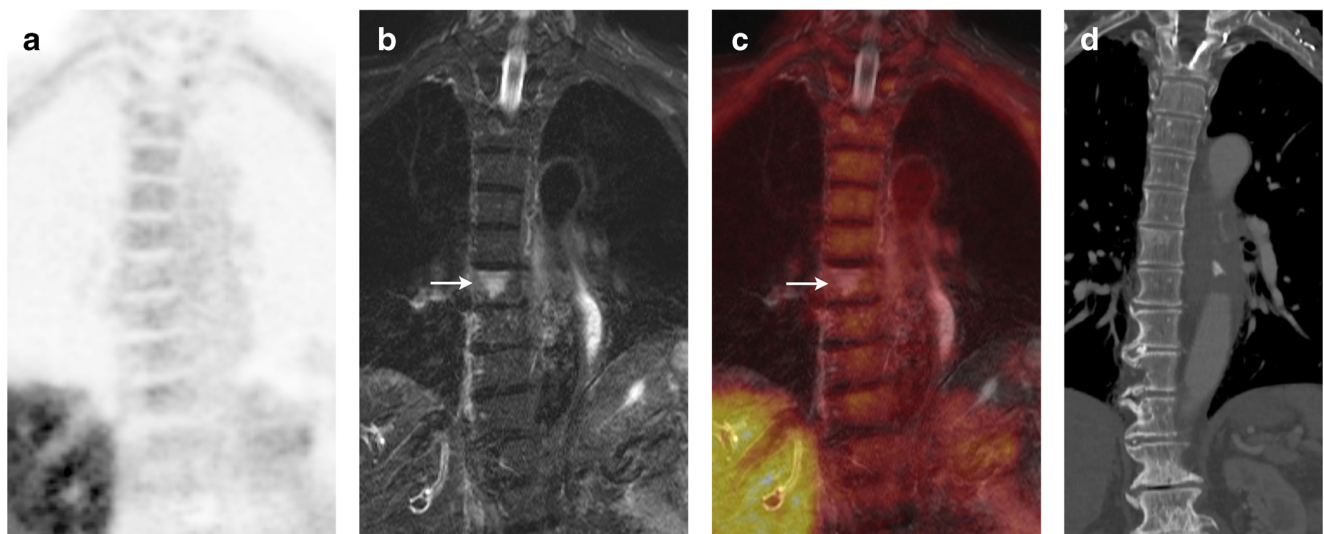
Fluciclovine-PET/MR physiological uptake throughout the bone marrow may mask detection of metastases. Fluciclovine-PET (a), STIR from MR (b), fluciclovine-PET/MR (c), and corresponding CT (d).
